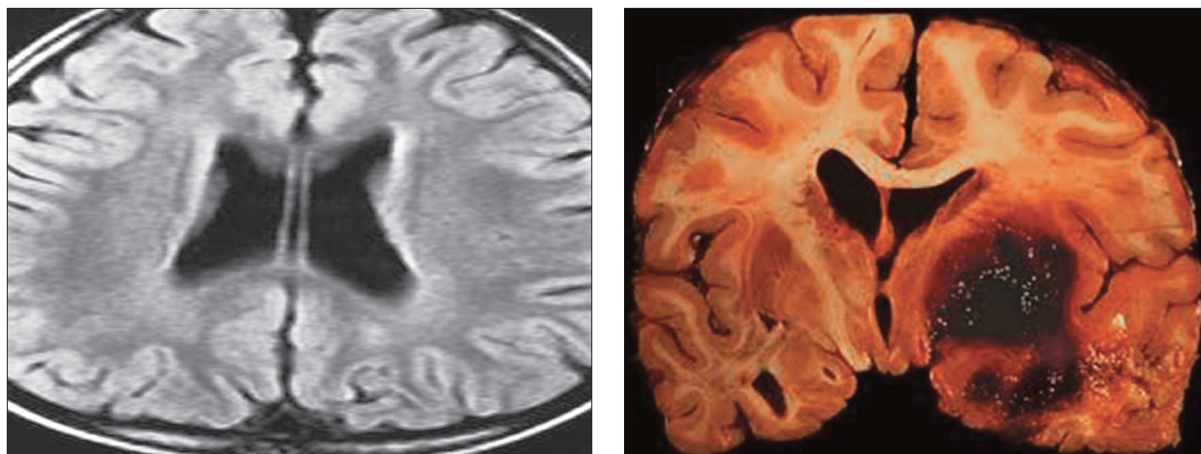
Hypertensive intracerebral hemorrhage on CT scan (left) and pathological appearance (right).
